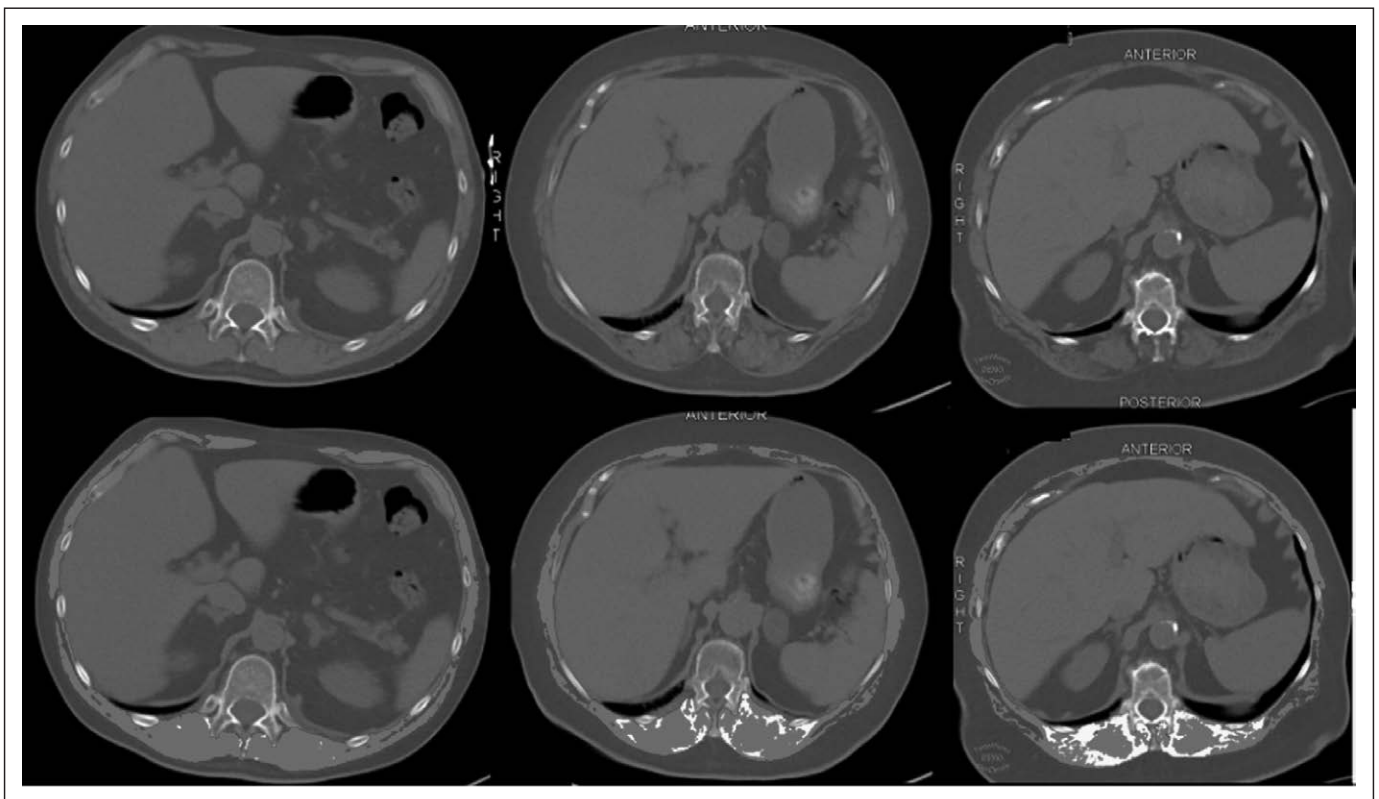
CT-derived skeletal muscle analysis at the 12th thoracic vertebrae level, showing skeletal muscle area and intermuscular adipose tissue surrounding erector spinae muscle. *Top row* shows high-resolution CT slices of three patients without tissue marking and *bottom row* shows the same slices with tissue marking in order of increasing intermuscular adipose tissue area.
